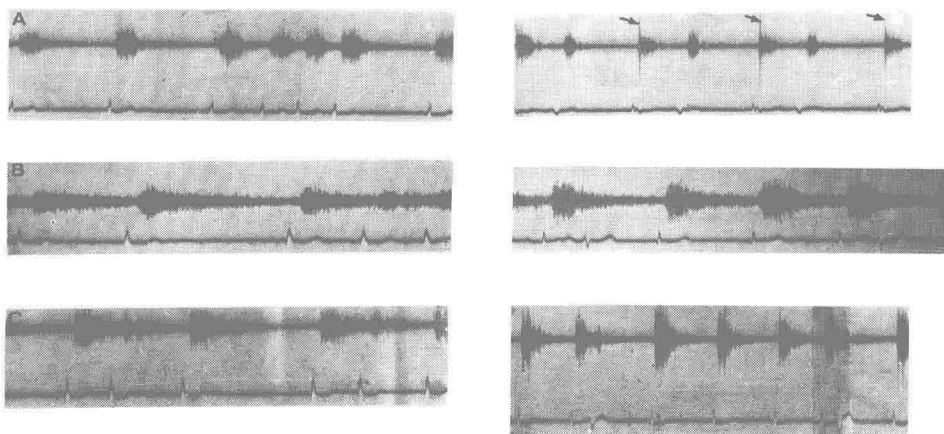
Effect of arrhythmia on the blood flow patterns in internal carotid artery. Left, indicates blood flow patterns in auricular fibrillation and right, in premature beat. (↓) indicates the Doppler beat due to the pulsation of blood vessel.
